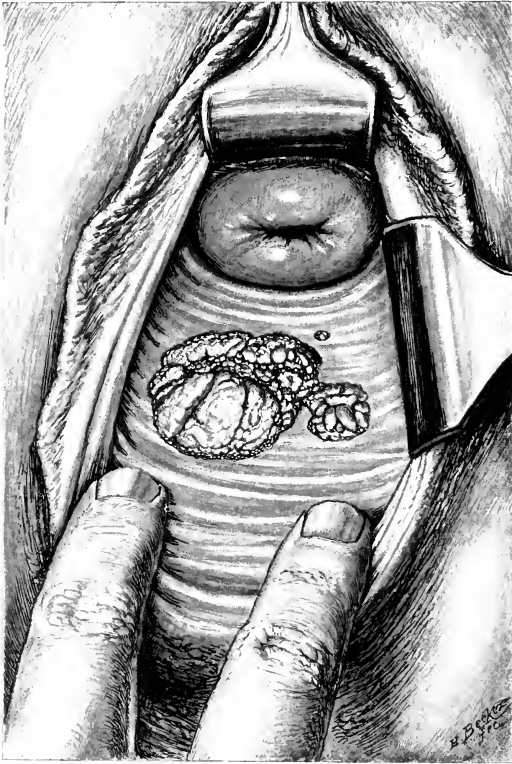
A CASE OF ADENO-CARCINOMA OF THE POSTERIOR VAGINAL WALL BY IMPLANTATION FROM AN UNSUSPECTED ADENO-CARCINOMA OF THE BODY OF THE UTERUS.
